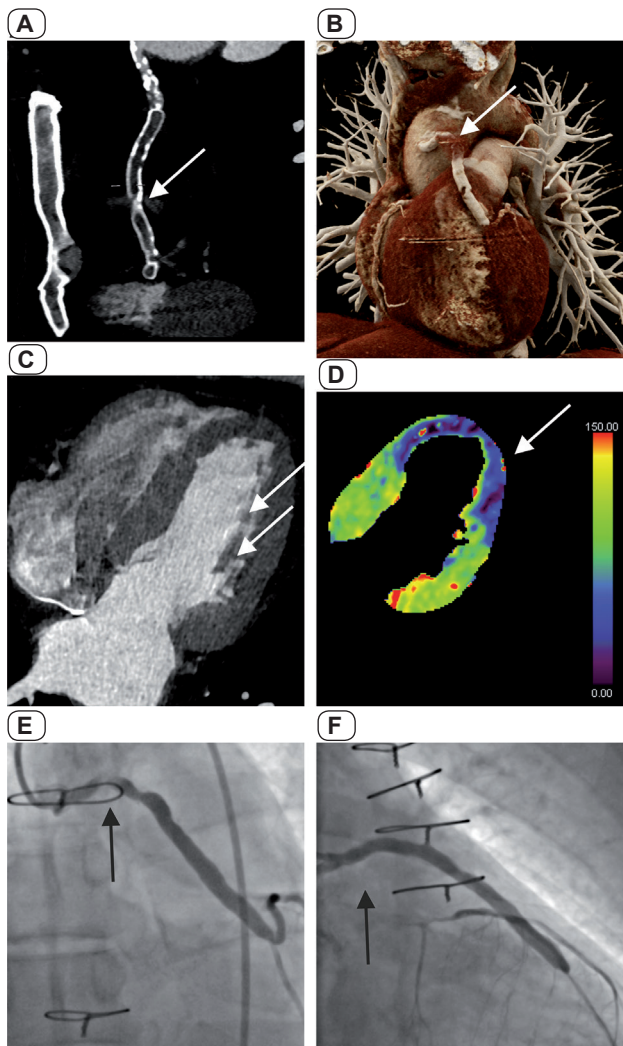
Representative images of a 71-year-old man with post-coronary artery bypass grafting to the LAD (left anterior descending artery), revealing significant stenosis in the vein graft resulting in scar formation in the lateral wall of the left ventricle. MIP (maximal intensity projection) (A) and corresponding 3D reconstruction VRT (volume rendering technique) (B). MPR (multiplanar reconstruction) (C) along with reduced perfusion (D) evaluated using computed tomography perfusion (CTP). The dual source 3rd generation CT Somatom Force device (Siemens Healthcare GmbH) was used to acquire the image. The images below display percutaneous transluminal coronary angioplasty before (E) and after (F) stent implantation into the vein graft.
